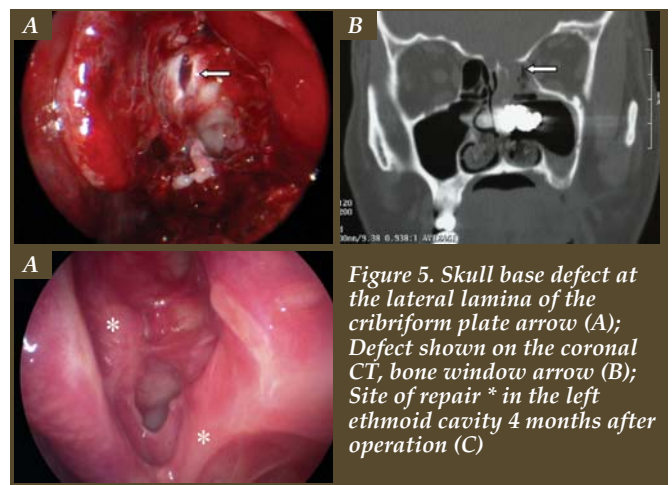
Skull base defect at the lateral lamina of the cribriform plate arrow (A); Defect shown on the coronal CT, bone window arrow (B); Site of repair \* in the left ethmoid cavity 4 months after operation (C)
